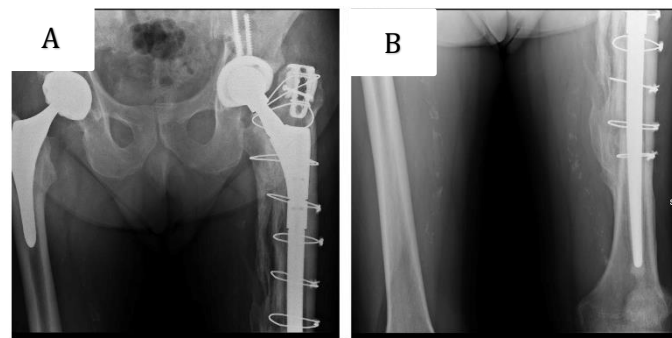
Radiographic anteroposterior (A) and axial view (B) at 3.2 years of follow-up showing the complete fracture healing, the good position of the acetabular component, and subsidence of the femoral stem without progressive radiolucent lines
